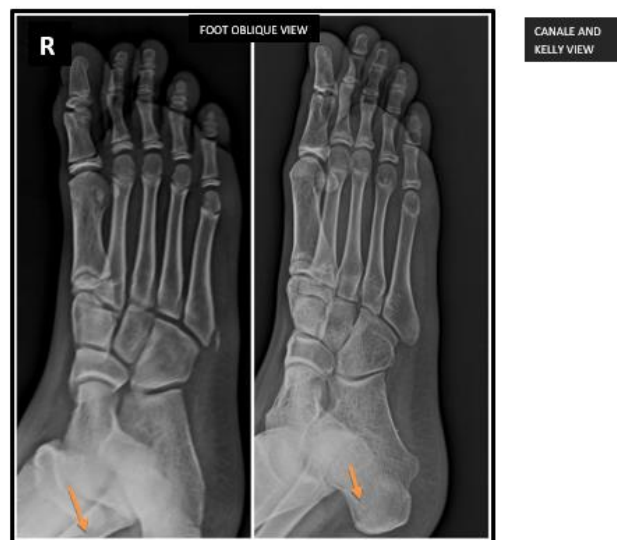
A 52 years old male came to the department of radio-diagnosis for radiographic examination of her right foot for the complaint of road traffic accident. The patient was advised to take Canale and Kelly view which gave the finding of transient osteoporosis.
